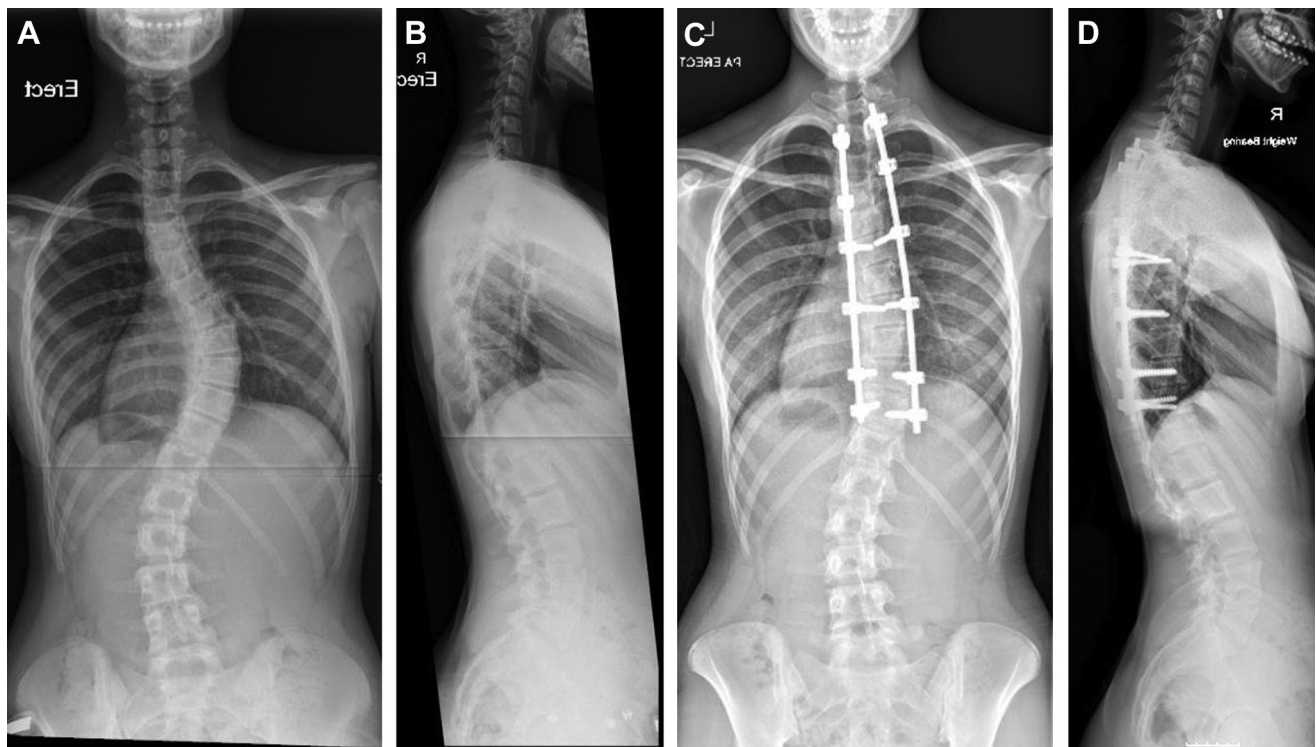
Example of a patient with a Lenke 1C curve who underwent selective thoracic fusion. Distal fusion level is at T11. (A) Preoperative posteroanterior radiograph; (B) preoperative lateral radiograph; (C) posteroanterior radiograph taken 2 years postoperative; (D) lateral radiograph taken 2 years postoperative.
